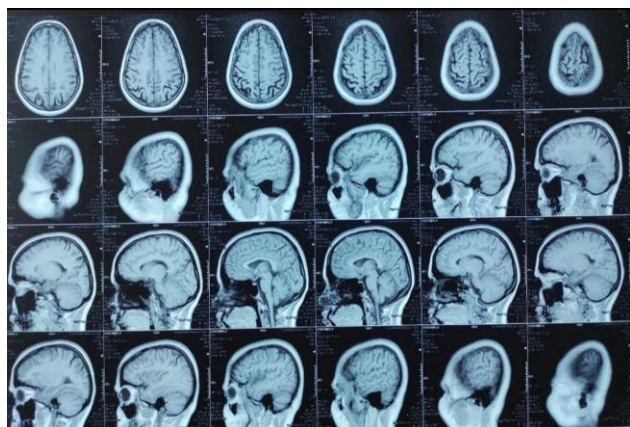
MRI brain imaging of the patient-normal.
